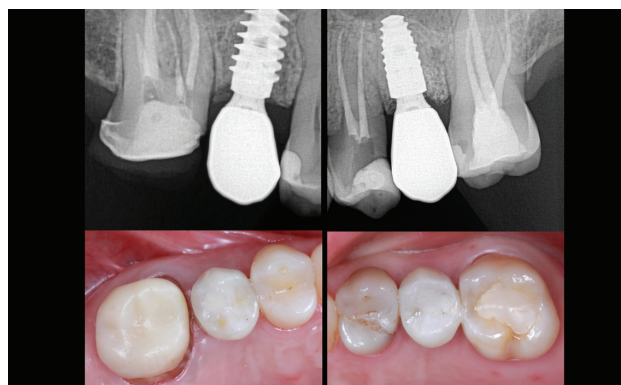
1-Year Follow-up – Occlusal photo and periapical radiograph with stable soft and hard tissue levels.
